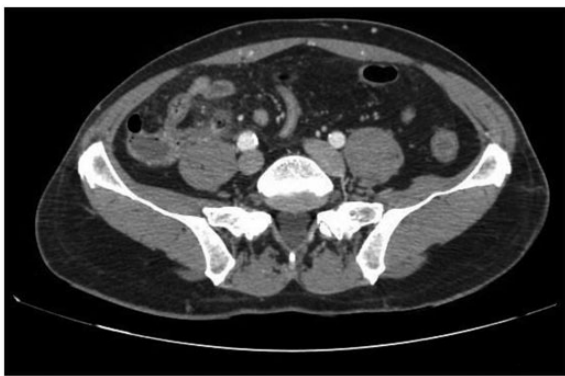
Coronal computed tomography images of the described patient. Note air in the appendix.
